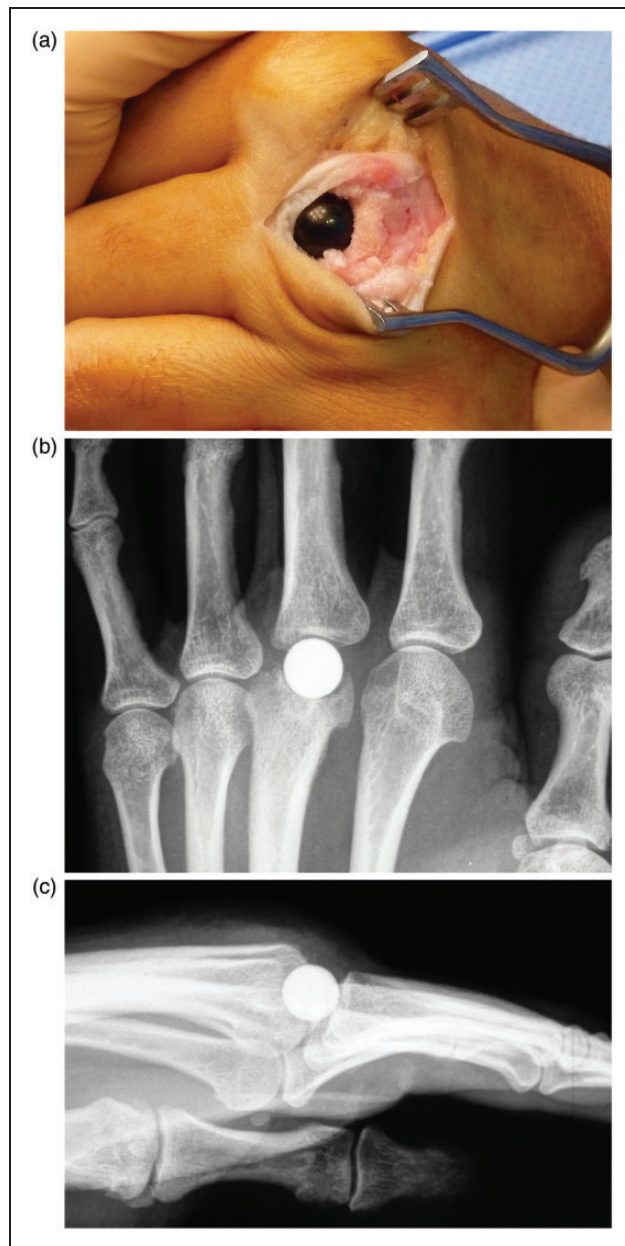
HAPY implant for treatment of OA of the third MCP joint of a 36-year-old manual worker. (a) Insertion of a HAPY implant. (b) and (c) Plain radiographs 9.5 years after surgery.
